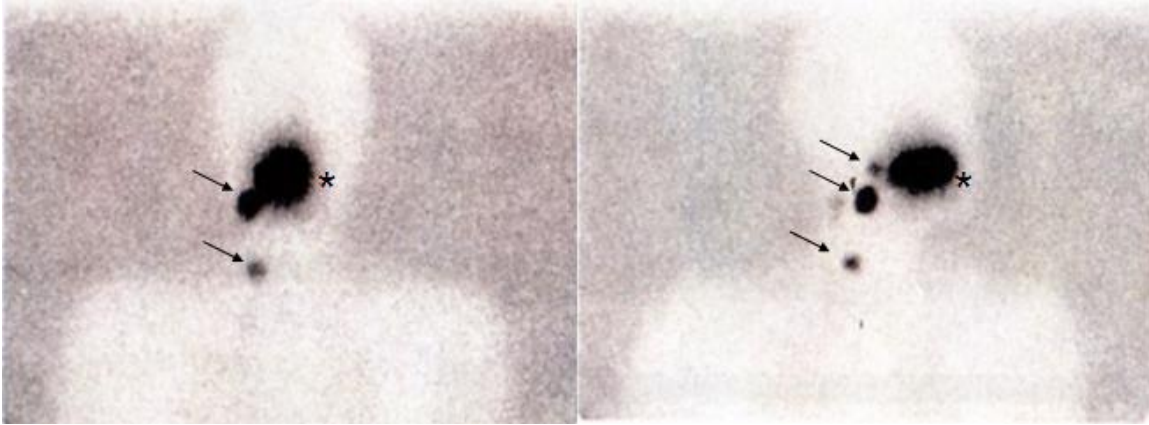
Lymphoscintigraphy; radioactivity seen from injection site around the primary tumour () and the sentinel nodes (arrows).*
